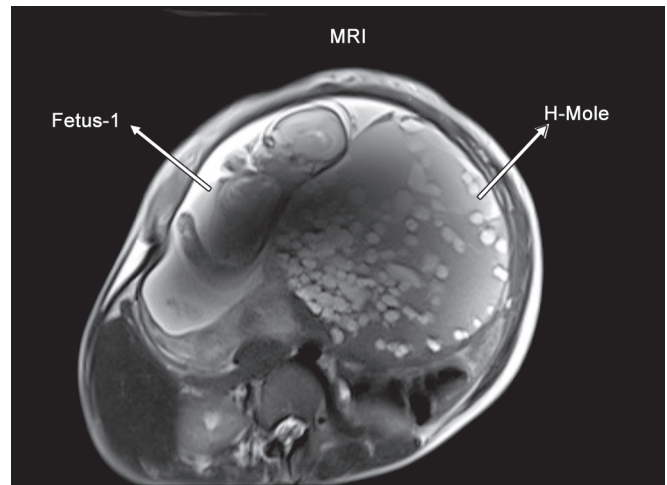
MRI image showing huge vesicular mole with one live fetus (case 3)
